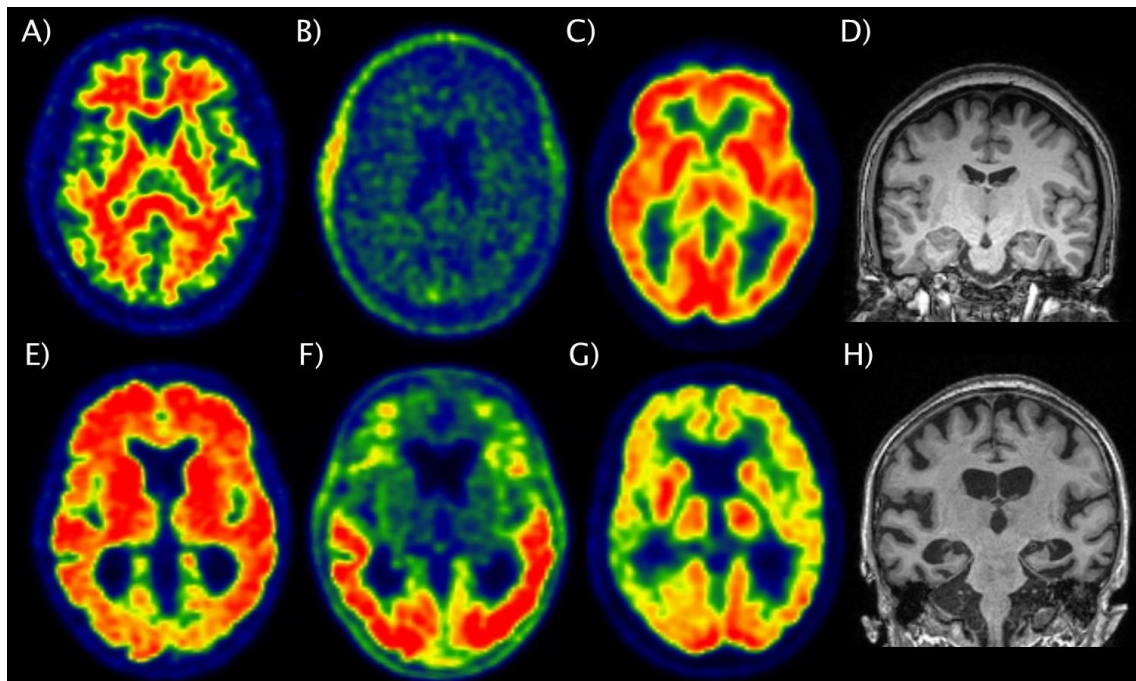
Multimodal neuroimaging hallmarks of DSAD. Representative images encompassing amyloid-PET (A, E), tau-PET (B, F), ¹⁸F-FDG-PET (C, G), and structural MRI (D, H). A-D depicts a 46-year-old cognitively stable individual with DS, demonstrating negative amyloid and tau burden, and preserved cerebral glucose metabolism and structural integrity. E-H) presents a 66-year-old individual with DS and AD dementia, characterized by widespread amyloid and tau positivity (with prominent parieto-temporal tau accumulation), reduced glucose uptake indicative of hypometabolism, and pronounced cortical and MTL atrophy.
